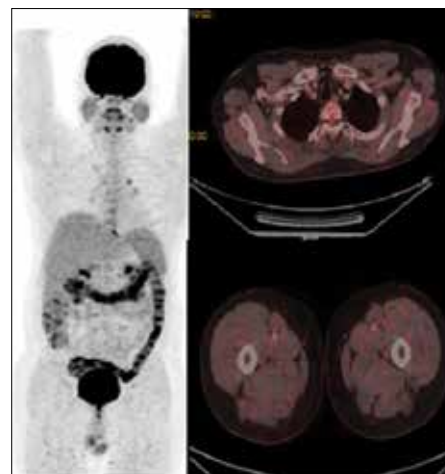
Positron emission tomography-computed tomography scan after 4 months of treatment showing near complete resolution of multiple minimally enhancing lesions in muscles of body
